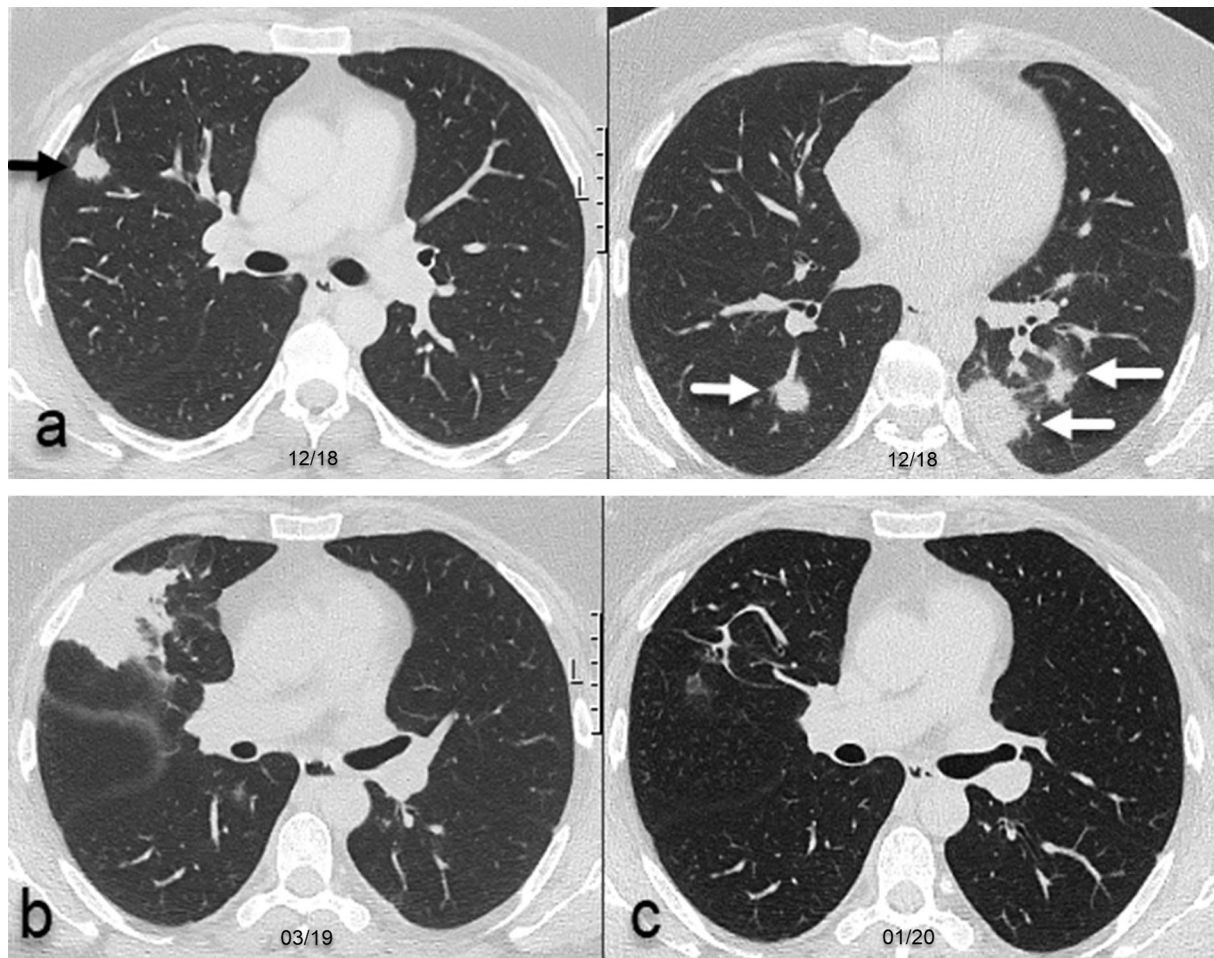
A: Axial pulmonary CT scan showing multiple lung masses with aerobronchograms and a lesion in the upper right lobe. Abbreviation: CT: Computer tomography.
